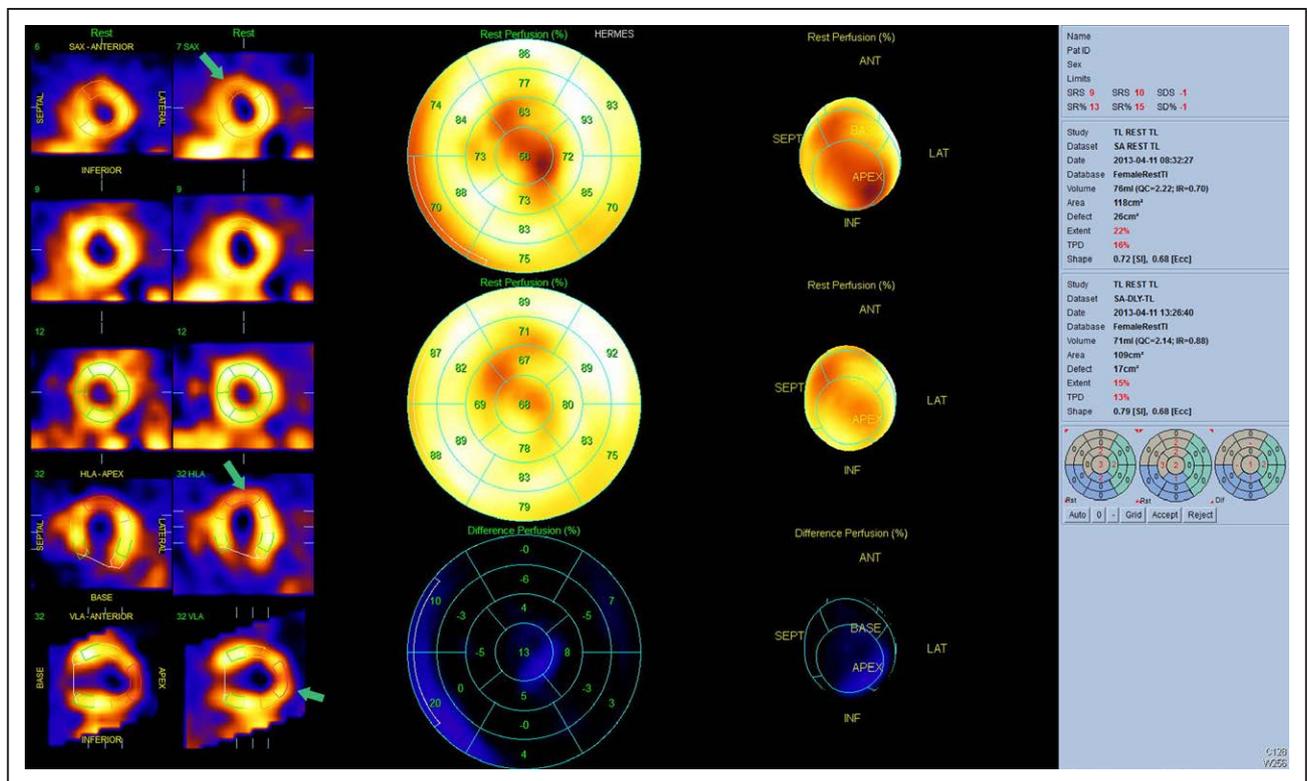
Rest and 24-hour redistribution single-photon emission computed tomography (SPECT) thallium-201 (²⁰¹Tl) study. A rest (left column, top bullet plot) and 24-hour redistribution (right column, bottom bullet plot) SPECT ²⁰¹Tl study demonstrates increased tracer uptake in the anterior (ANT), septal (SEPT), and apical segments after 24 hours (arrows), consistent with viable myocardium in this territory. HLA indicates horizontal long axis; INF, inferior; LAT, lateral; SAX, short axis; and VLA, vertical long axis.
